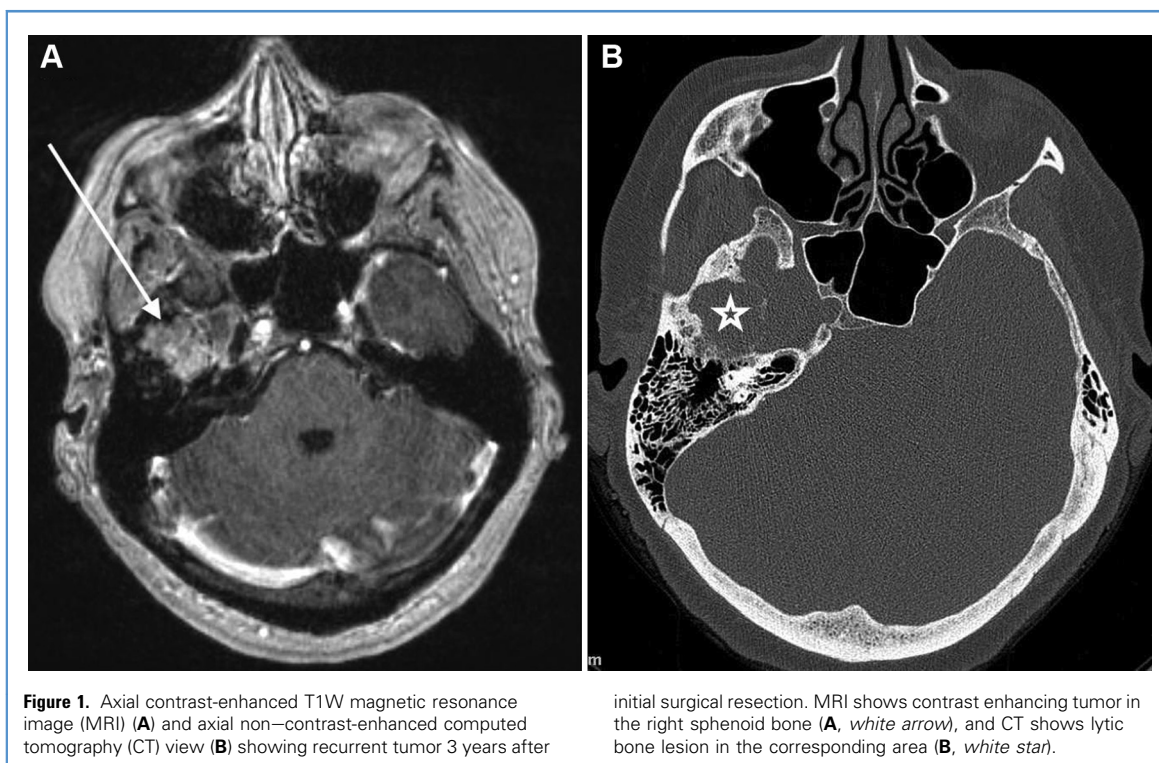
Axial contrast-enhanced T1W magnetic resonance image (MRI) (A) and axial non-contrast-enhanced computed tomography (CT) view (B) showing recurrent tumor 3 years after
